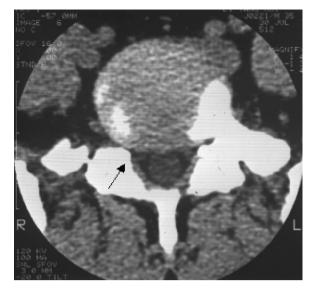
The CT scan after the treatment. The arrow showed size and position of L4–5 lumbar disc herniation after the treatment at the 12 months.
